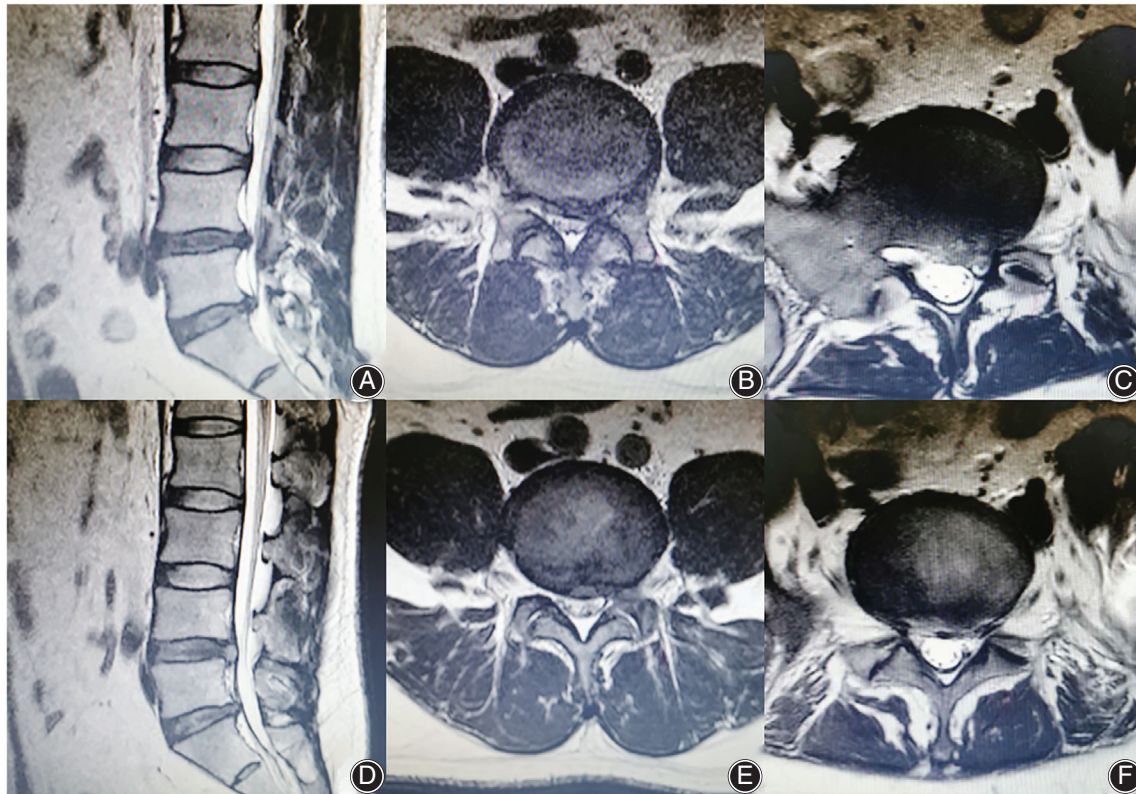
A 49-year-old male patient. (A–C) The preoperative MRI revealed L4/5 and L5/S1 two-level disc herniation. (D–F) Postoperative MRI (Day 3) showed that the compression was released.
